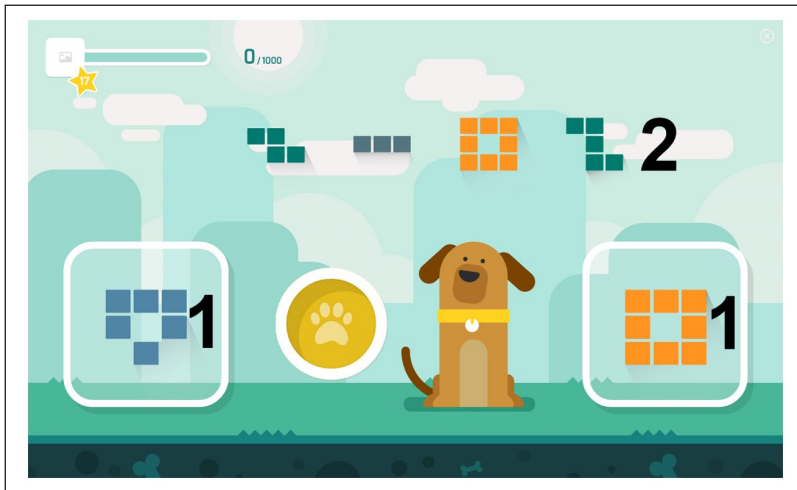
CT game user interface.
